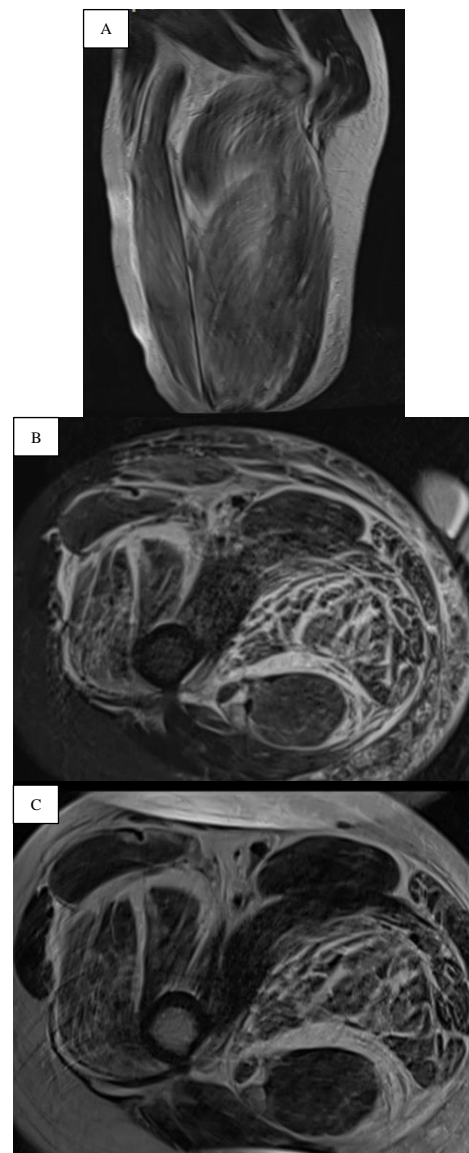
Magnetic resonance imaging (MRI) of the right thigh
